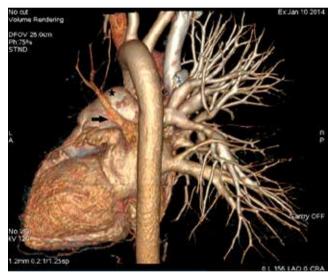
High resolution computed tomography reconstruction – absence of the left pulmonary artery (star), reduced diameter of left-sided pulmonary veins (arrow)
